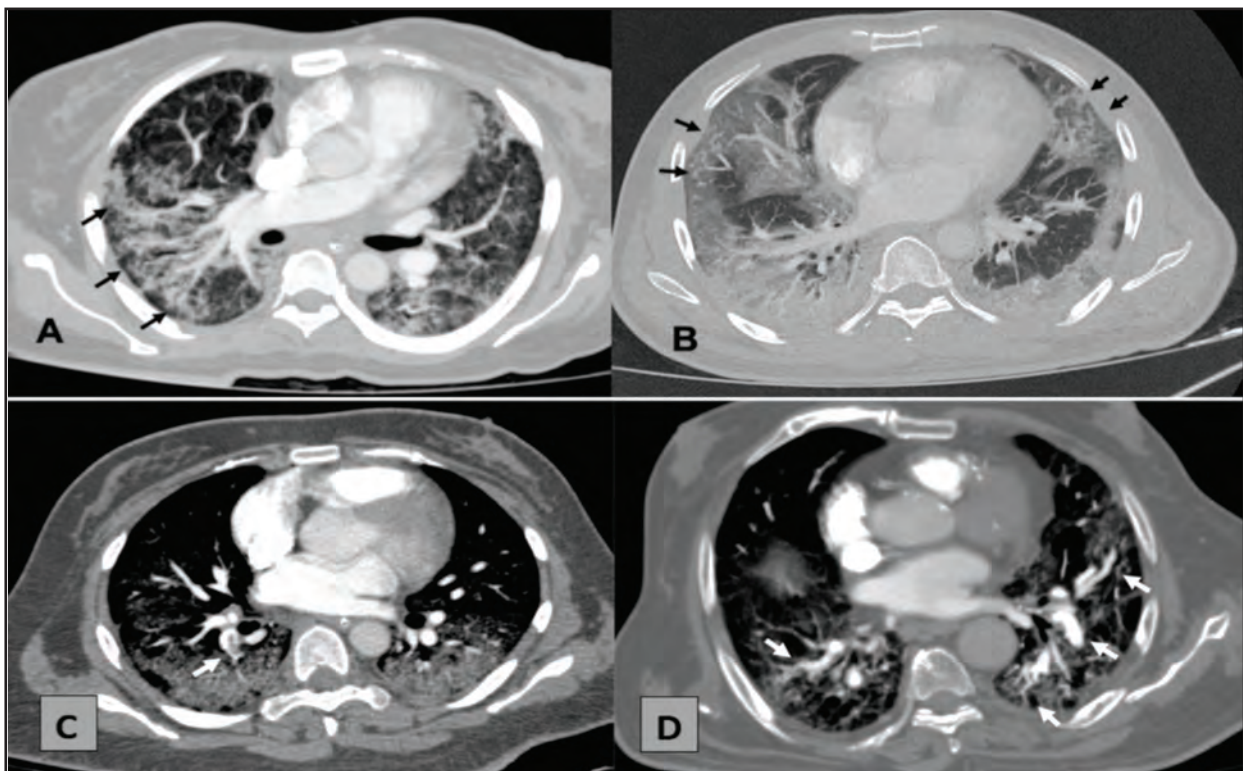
Axial slice of CTPA demonstrates features of pulmonary angiopathy in two patients with severe COVID-19 pneumonia. (A) Image showed dilated branching and tortuous vessels in the right lower lobe (arrows). (B) There is a bilateral ground-glass opacification with consolidation and vascular tree-in-bud pattern distally, a sign of angiopathy (arrows). (C) CTPA of patient with COVID-19 pneumonia, day 10 after intubation demonstrates filling defects in right lower lobe pulmonary arteries (arrows). (D) CT of elderly patient at day 14 of illness showed dilated branching and tortuous vessels in both lower lobes representing features of pulmonary angiopathy
